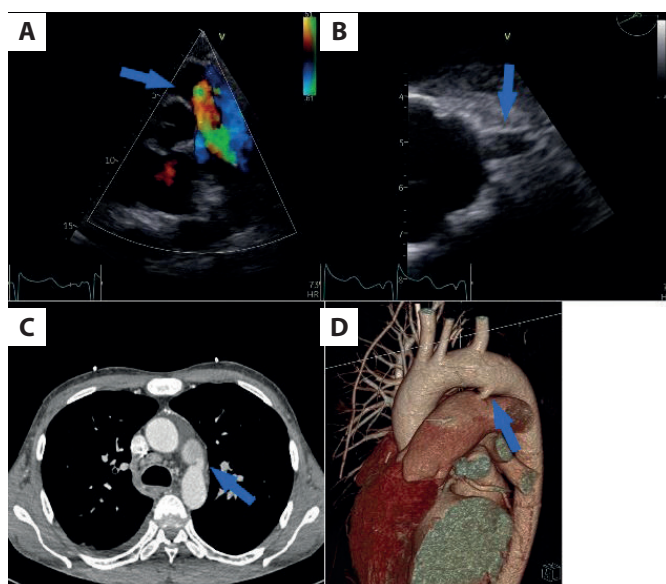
A. Transthoracic echocardiography color Doppler: blood flow from the aorta to the pulmonary trunk (arrow). B. PDA visible on transesophageal echocardiography (arrow). C. PDA on CT angiography (arrow). D. PDA on CT angiography 3D reconstruction (arrow)
